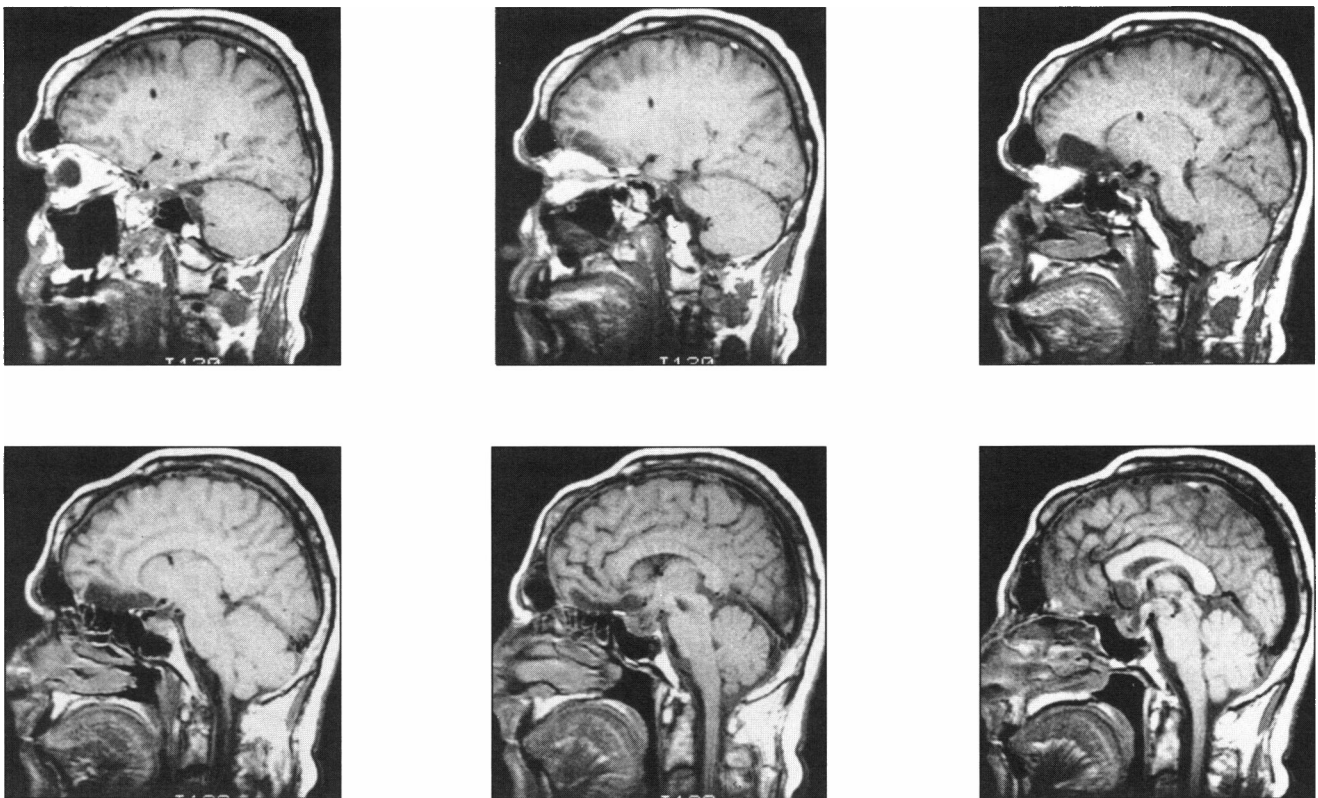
Sagittal MRI scans show the zone of cerebral damage described in Fig. 1. Note sparing of the frontal cortex anterior to this zone and the post-operative abnormality in the sellar region.
